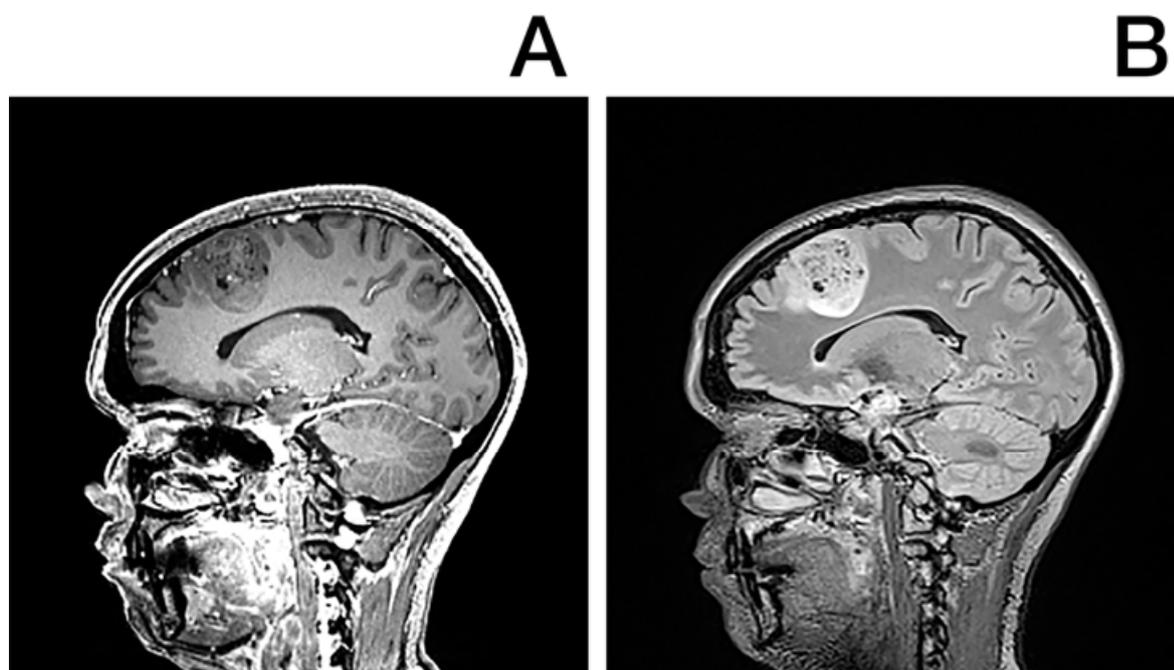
Magnetic resonance images of low-grade glioma on T1-weighted (A) and T2-weighted FLAIR (B) images.
